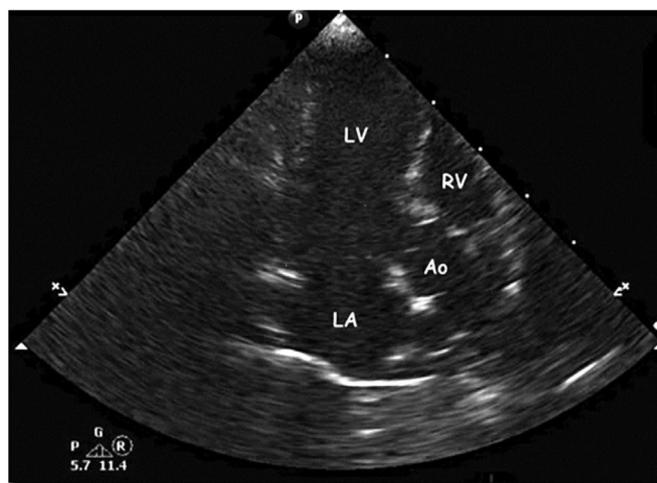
Echocardiographic view of left atrium (LA), left ventricle (LV), right ventricle (RV), and aorta (Ao).
